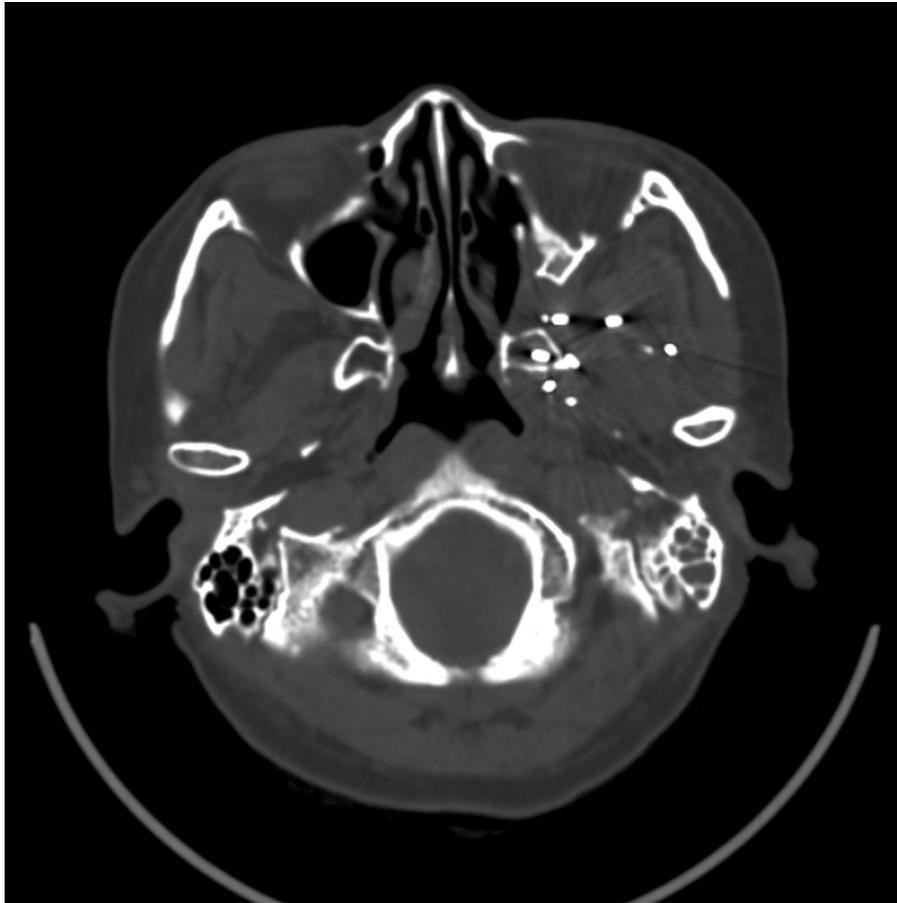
Computed tomogram 16 months after treatment shows complete tumor response and no evidence of recurrence.
